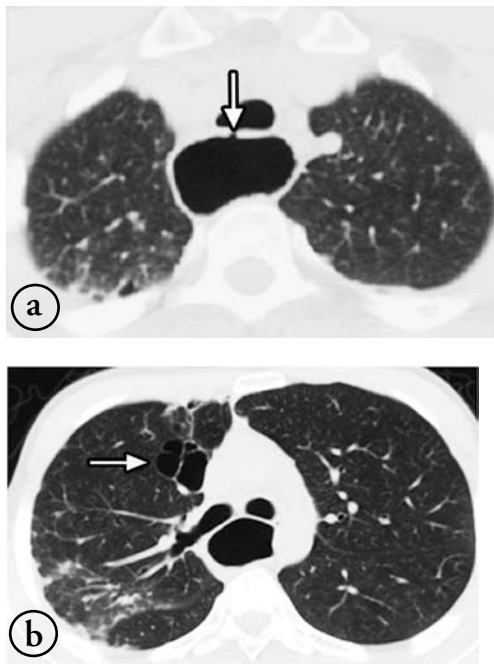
An axial CT scan of the chest lung window demonstrates: a) soft tissue defect between trachea and esophagus (white arrow) with marked dilatation of the esophagus with b) foci of bronchiectasis (arrow) in the right lung with area opacification resulting from chronic recurrent aspiration and infection.
